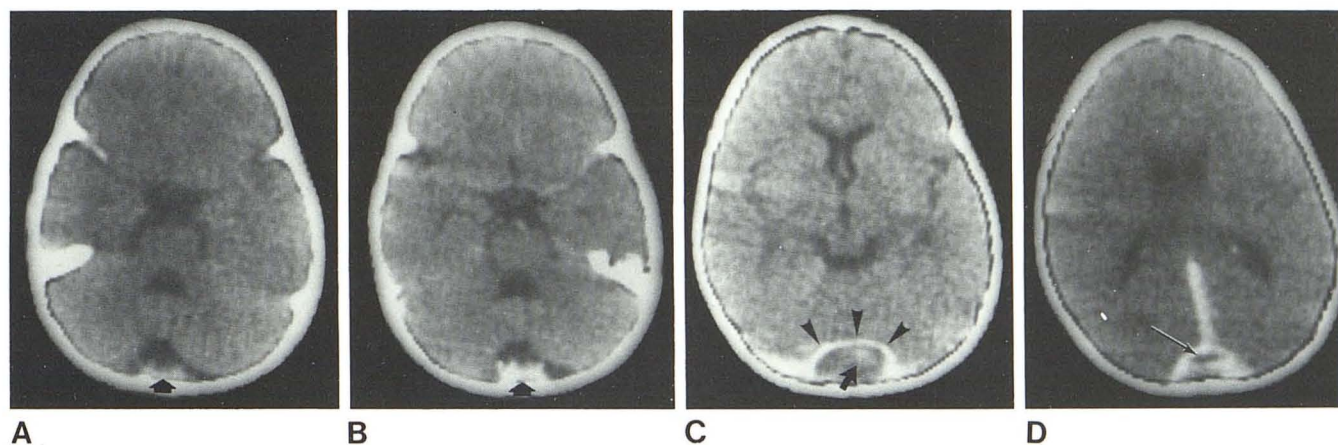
Secondary craniocerebral neuroblastoma with dural metastasis and venous thrombosis. A, CT scan without contrast material injection. Calcified mass (arrow) projects into cisterna magna from dura of calvarium. This represents the spiculated hair-on-end hyperostosis that can be seen on skull radiographs. B, Postcontrast at same level as A. Enhancement of tissue containing calcification (arrow). C, Postcontrast at level above A and B. Confluence of lateral sinuses is displaced forward (arrowheads) by partially enhancing tumor mass (arrow). D, Next level higher. Lucent filling defect (arrow) at juncture of straight and lateral sinuses. At autopsy, this was thrombus within sinus confluence.
